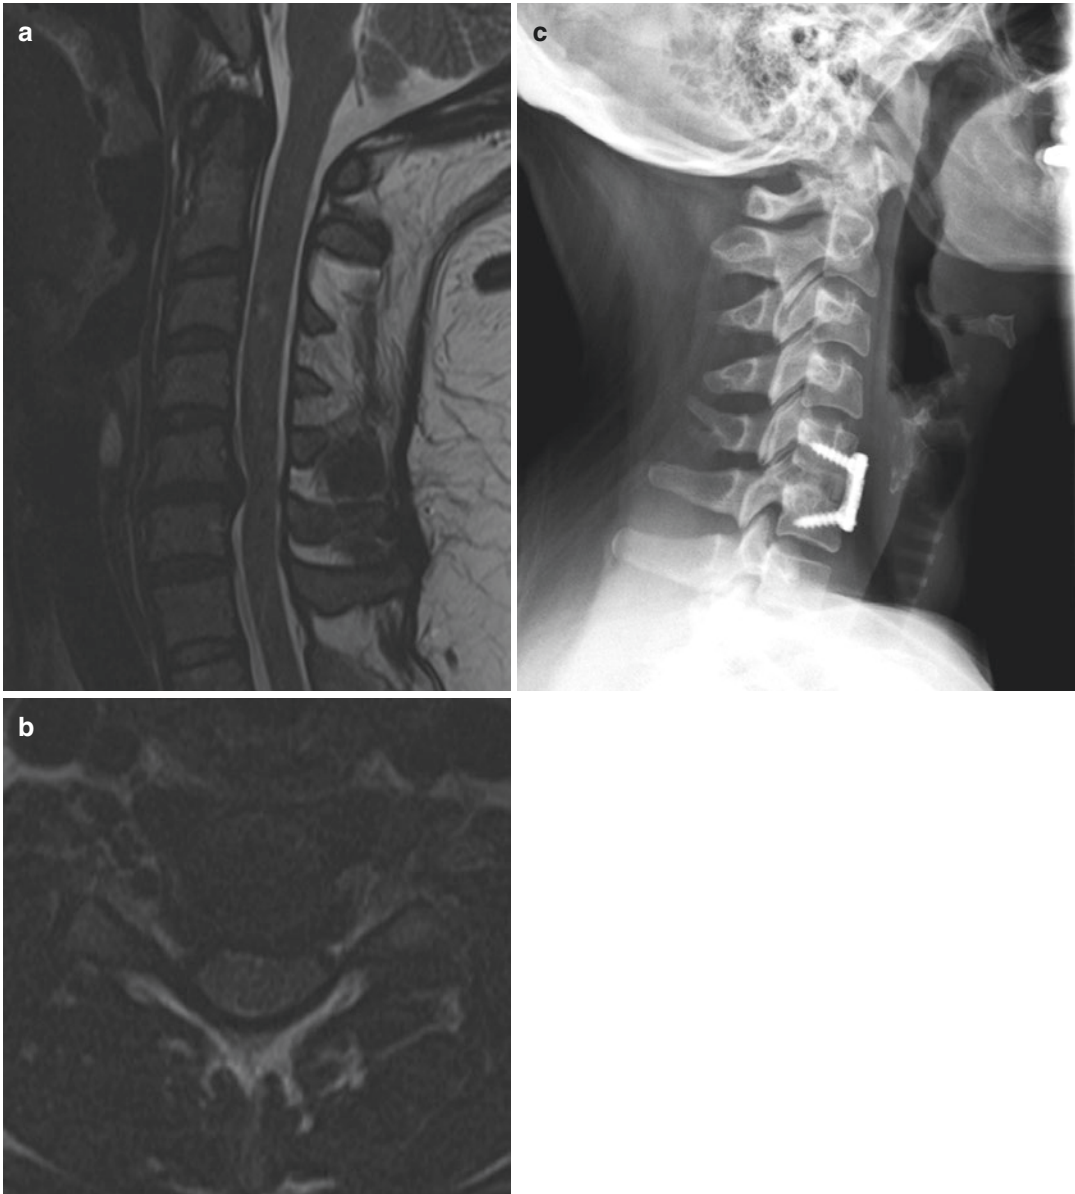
(a-c) Case 1. A 37-year-old female presents with symptoms of mid-scapular pain and pain radiating down the left arm. On neurologic exam, the patient had subtle left wrist extension weakness and numbness to her left thumb. Reflexes were normal except for a slight diminished left brachioradialis reflex. Sagittal T2-weighted cervical MRI demonstrates a disc protrusion at the C5–C6
